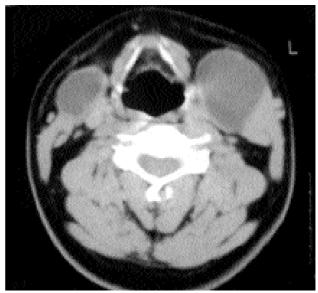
Axial computed tomography image showing both cystic masses located in front of the carotid sheath.
